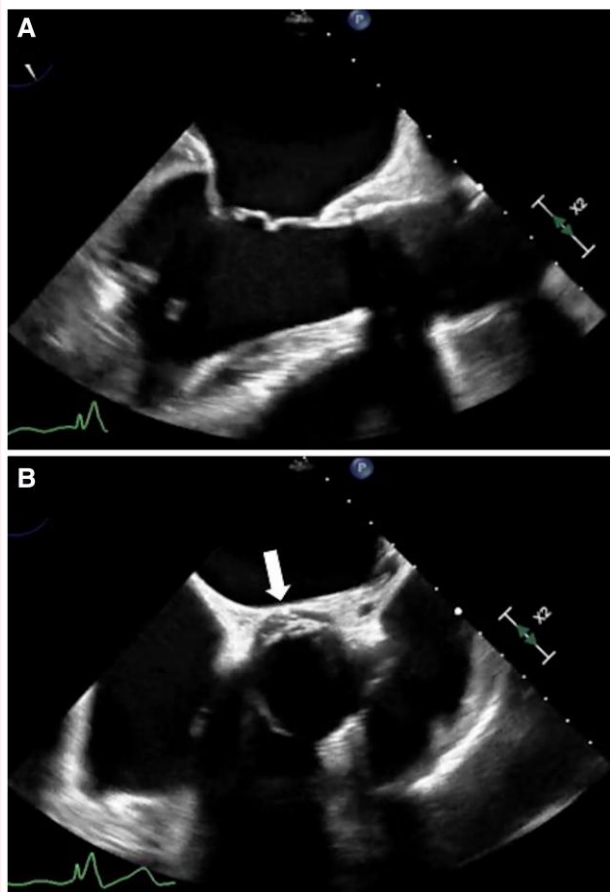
Transoesophageal echocardiogram images of bioprosthetic aortic valve by (A) long-axis and (B) short-axis views. Although the long-axis image demonstrates stable findings compared with [Figure 1B](#), the short-axis images demonstrate a more prominent fluid space than previously recognized. This tomographic plane is more inferior (lower in the aortic root); therefore, it is challenging to determine whether this represented an evolving fluid space or a different representative tomographic plane.
